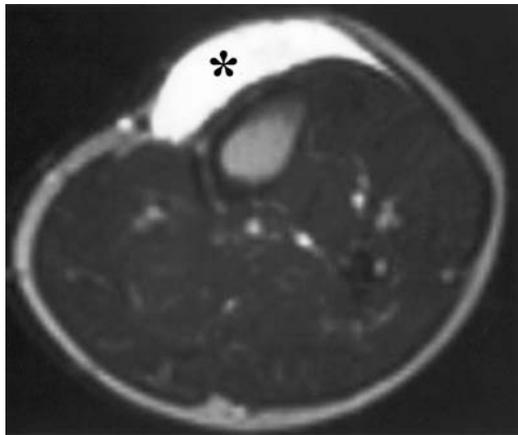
Subcutaneous myxoma in the lower leg of a 32-year-old man. Axial T2-weighted (2500/90) SE MR image shows a well-defined subcutaneous mass (*) anterior to the tibia. The large size of the lesion makes it difficult to determine whether its origin is in subcutaneous tissue or the aponeurosis.
